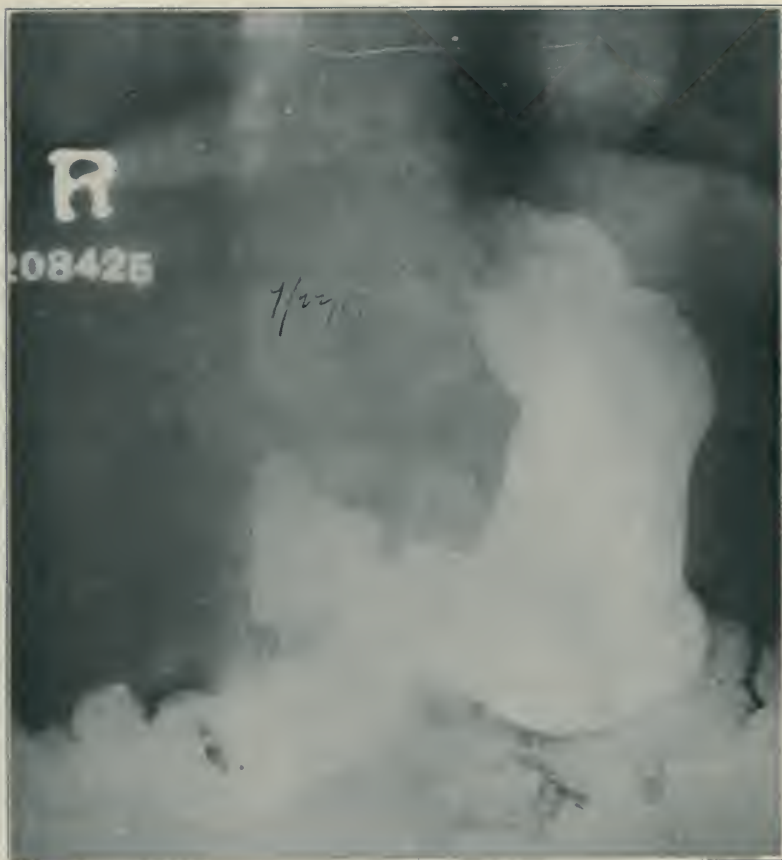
(208425.) Syphilis of the pars cardiaca, rare form, easily mistaken for carcinoma. Patient, male, age 33. Primary lesions twelve years previously, gastric disturbances $1\frac{1}{2}$ years. Distress after food in epigastrium. Six months ago onset of emesis after all food except milk and small amounts of milk toast. Wassermann ++++ (9/20/17). Roentgen ray diagnosis: inoperable carcinoma of the stomach. Filling defect cardia. Intensive course of treatment here with marked improvement. Gained 17 pounds. Ravenous appetite. Wassermann negative 10/20/17. Roentgen ray 11/5/17. Condition shows marked anatomic improvement. To date patient is clinically cured. He reports that he is feeling fine with no gastric symptoms whatsoever.
